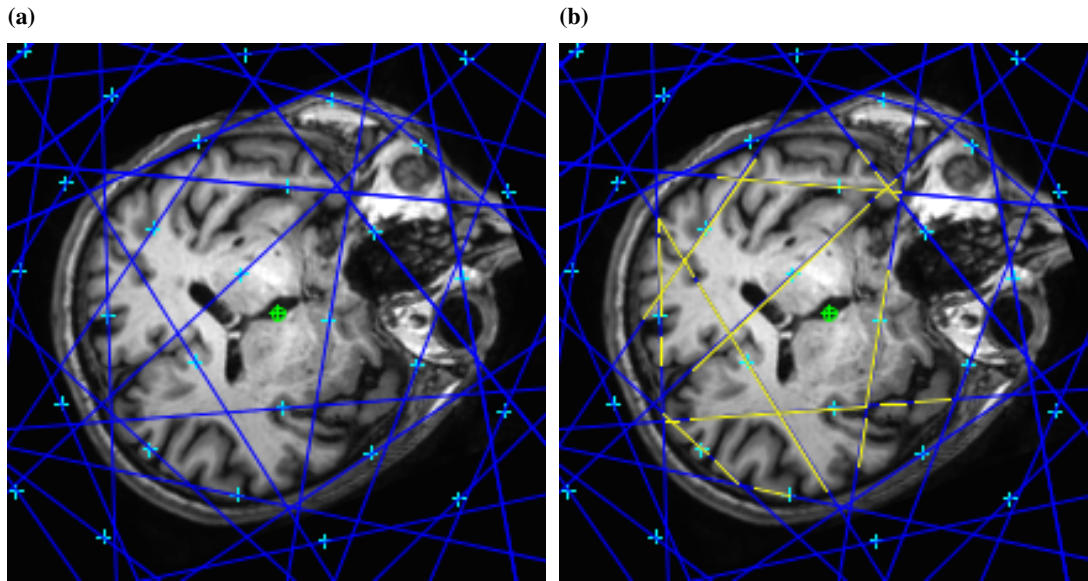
Length measurement of segments covering whole brain tissue on MR image for estimating whole brain volume by the INV method using the ‘measure_inv_dn.txt’ script. (a) Test grid and lines (blue) before the measurement; (b) test grid and lines (yellow) after the measurement.
